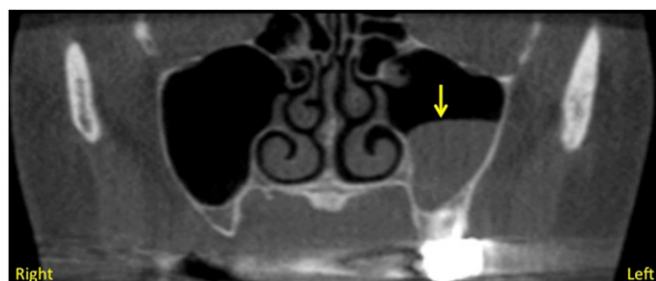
CBCT slice in the coronal plane showing the mucous retention pseudocyst (arrow).
